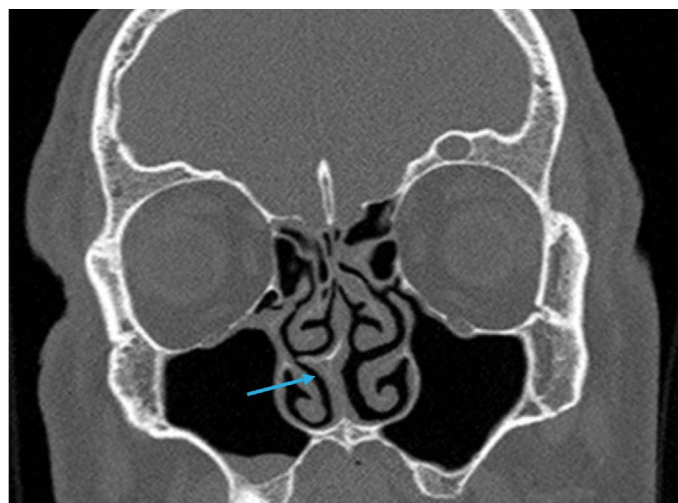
CT scan of sinuses in frontal projection. Visible right-sided curvature of nasal septum in the form of protruding nasal spine (blue arrow).
